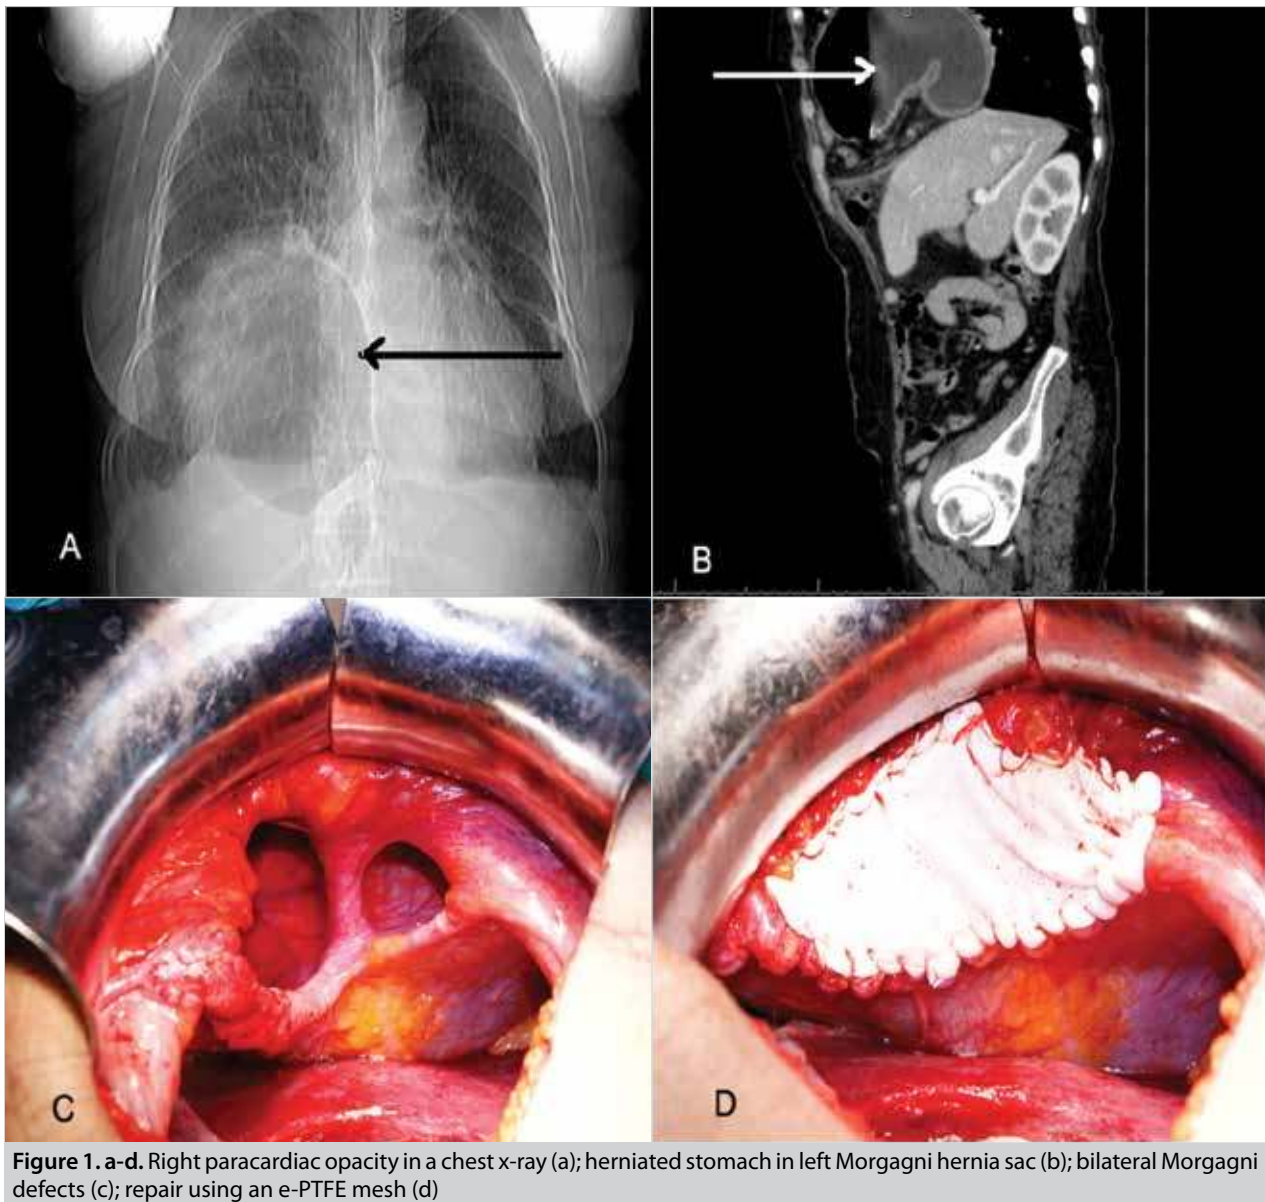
a-d. Right paracardiac opacity in a chest x-ray (a); herniated stomach in left Morgagni hernia sac (b); bilateral Morgagni defects (c); repair using an e-PTFE mesh (d)
